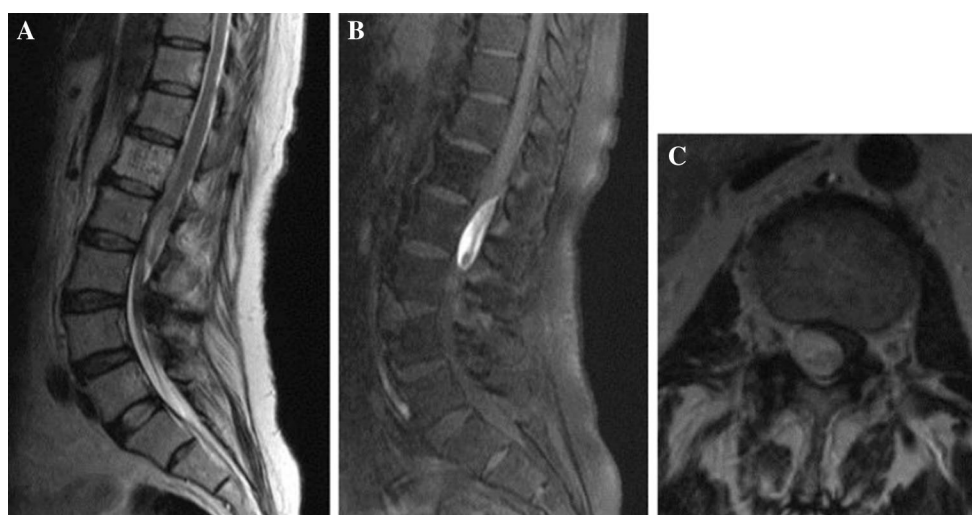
Case 2: preoperative images from a sagittal T2-weighted MRI, b sagittal T2-weighted FSE MRI, and c axial T2-weighted MRI revealed a spinal subdural hematoma at L2
